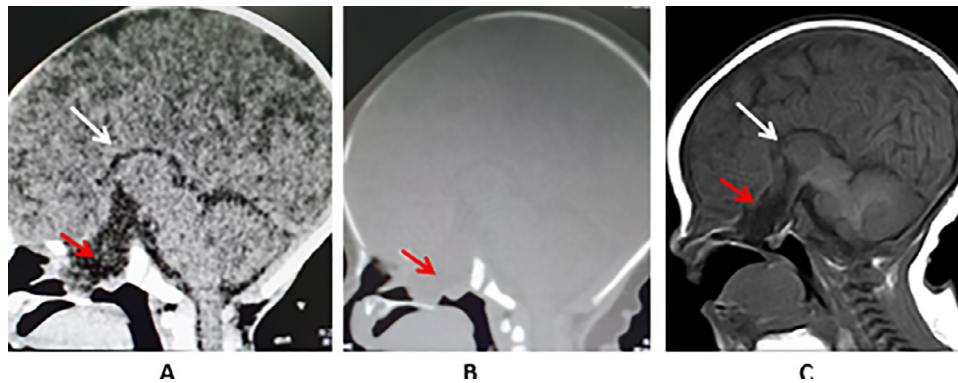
(A, B) Sagittal computed tomography soft tissue and bone window and (C) Sagittal T-1 weighted magnetic resonance imaging of the brain show complete absence of the corpus callosum (white-arrows) and midline sphenoid defect with herniation of the meninges and cerebrospinal fluid (red-arrows) (color version of figure is available online.)
